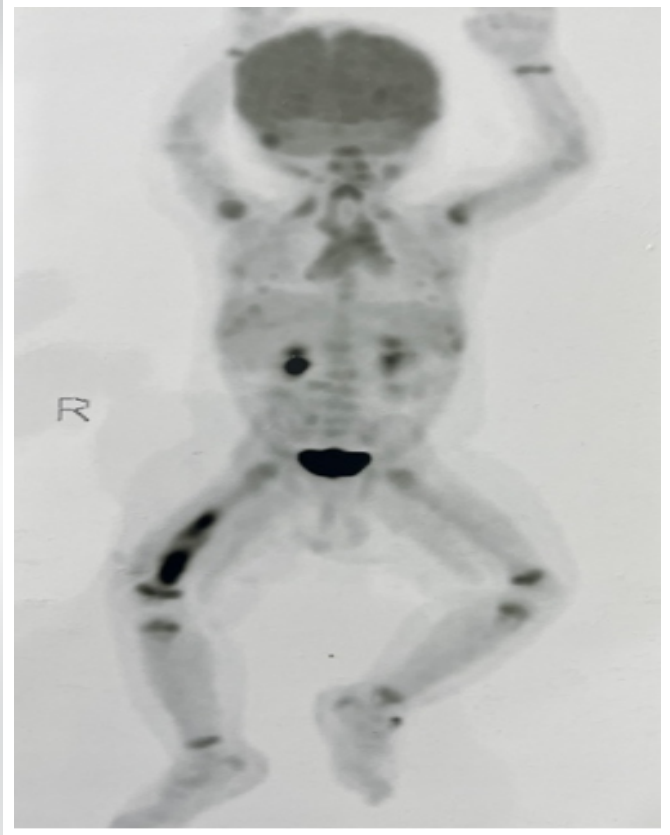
Positron emission tomography computed tomography – shows no other systemic involvement.
